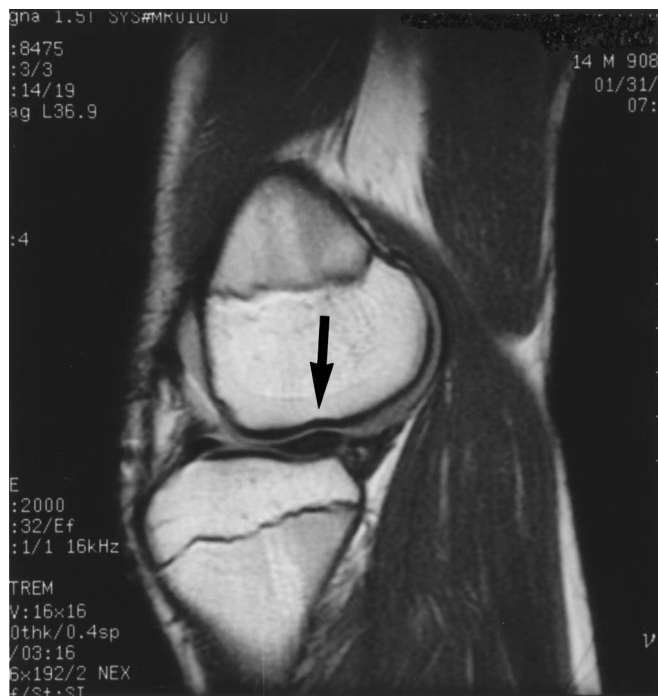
Patient 3. Sagittal MRI of the knee shows anterior displacement of the tibia and incarceration of the posterior horn of the medial meniscus within a large osteochondral defect (arrow).
